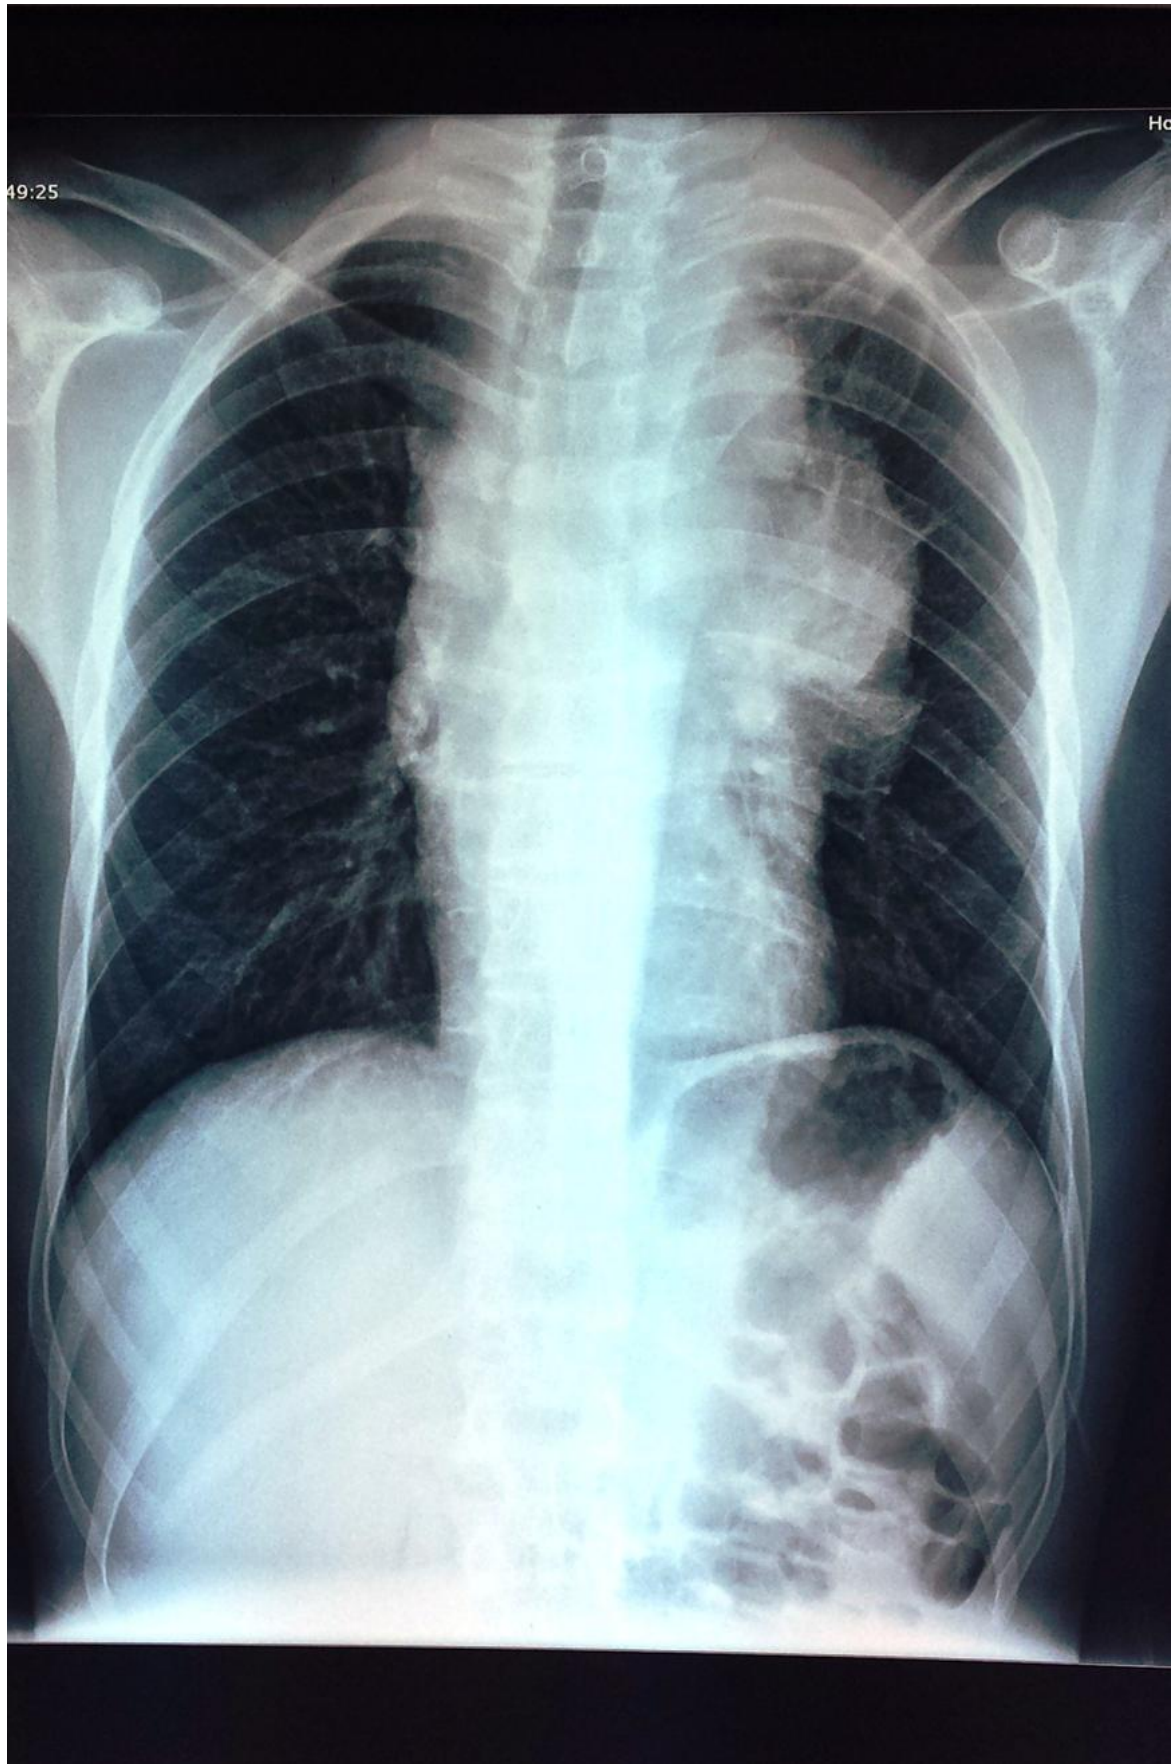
Standard chest X-ray showing a mediastinal opacity with polycyclic contours and displacement of the trachea towards the right side.
